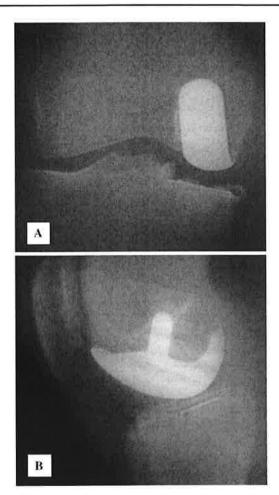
B (A) AP and (B) lateral radiographs taken 9 years after surgery show a Repicci II® prosthesis for medial compartment OA.
